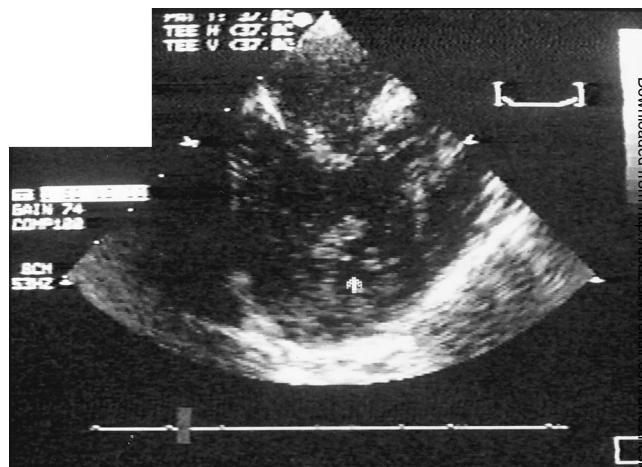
Transesophageal echocardiographic image of the patient's left atrium and single ventricle with thrombus in the ventricle and adjacent to the mitral valve (arrows).
